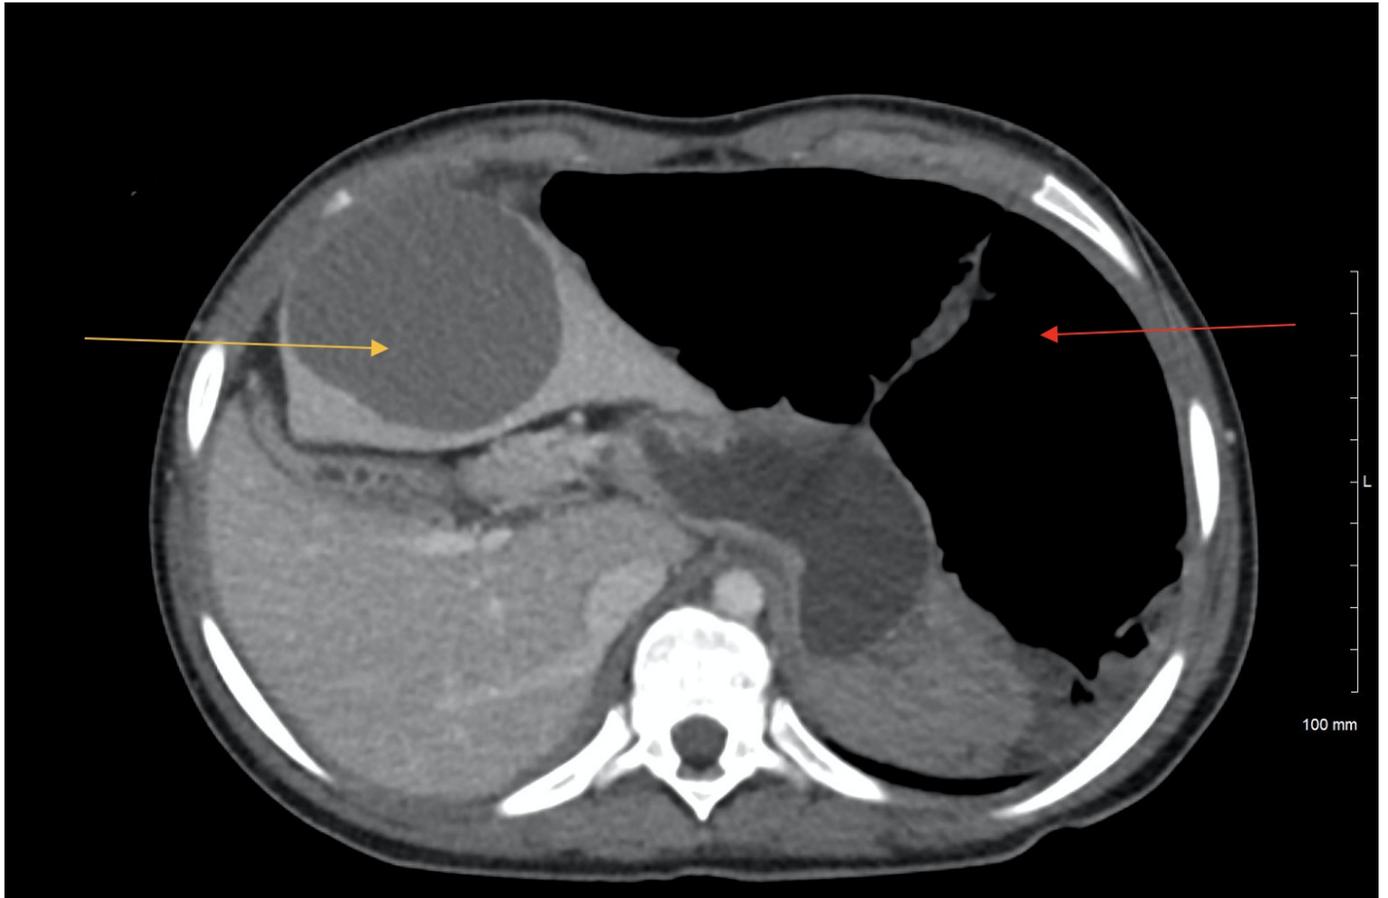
Computed tomography axial images showing right sided spleen with splenic cyst (yellow arrow) and colonic dilatation (red arrow).
